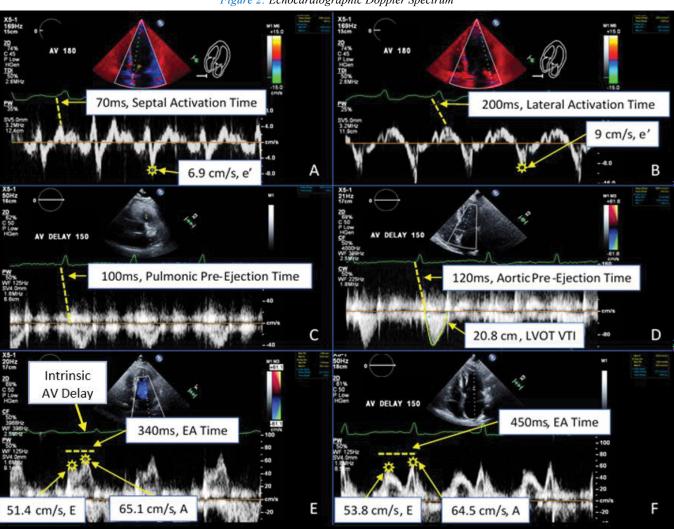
Echocardiographic Doppler Spectrum
